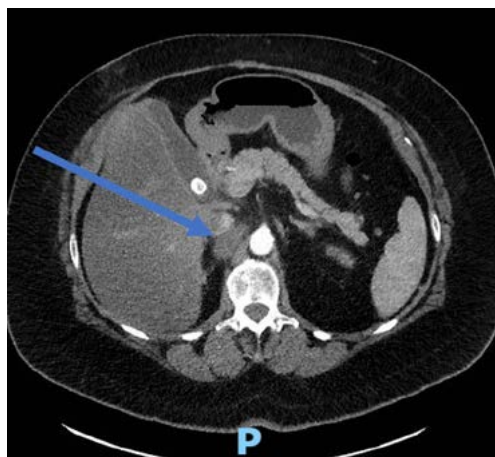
Post-treatment CT scan (19mm) on 12th May 2020 10 weeks after completion of SABR
